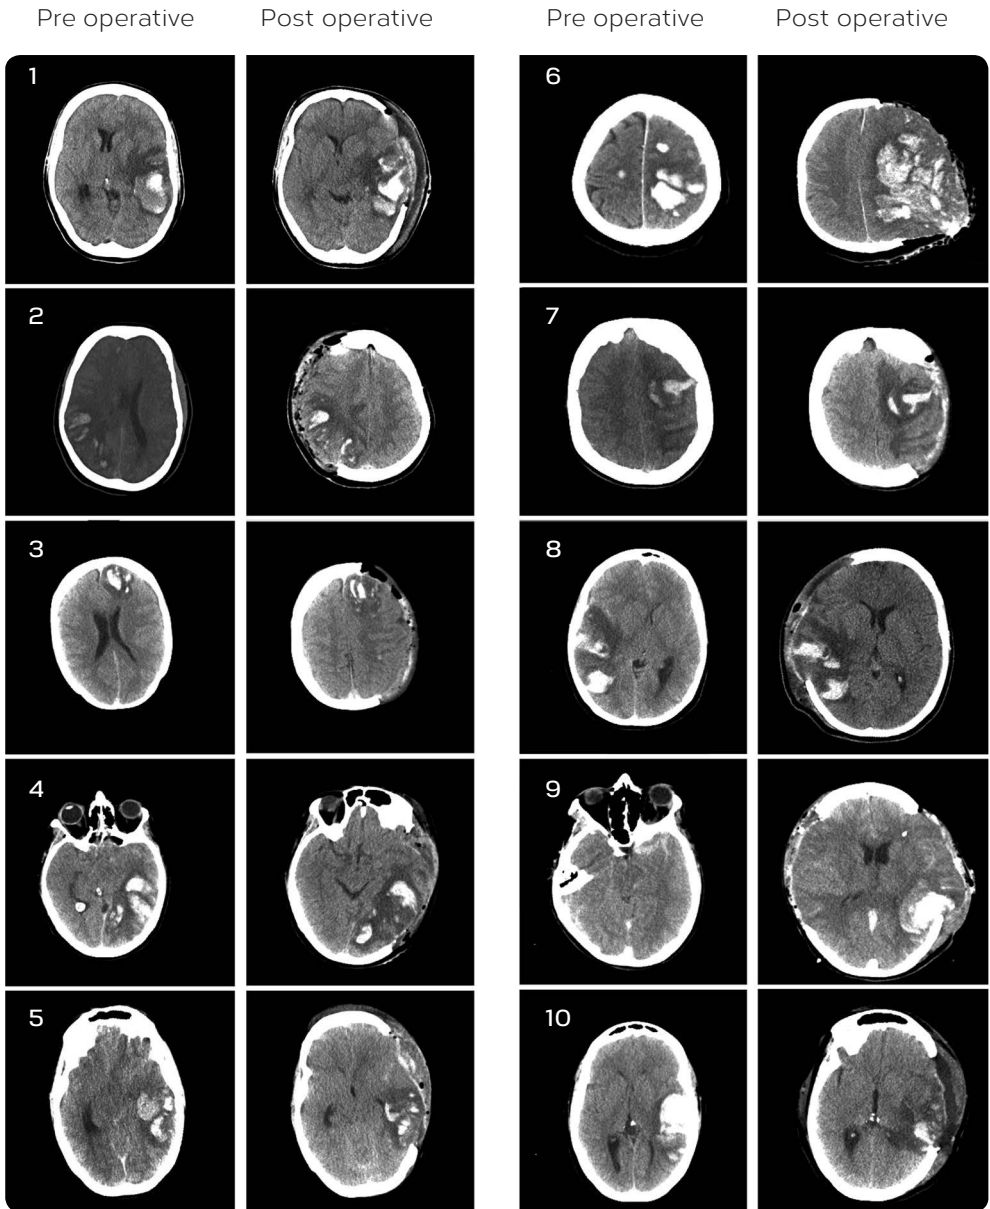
Pre- and post-operative CT scans of all 10 cases. All patients had space-occupying intracranial hemorrhagic infarcts except case 9. Case 9 had extensive subarachnoid bleeding, small bilateral hemorrhages, generalized cerebral edema and obliterated basal cisterns. Case 3 had besides the hemorrhagic infarct obliterated basal cisterns due to increased bilateral cerebral edema.
